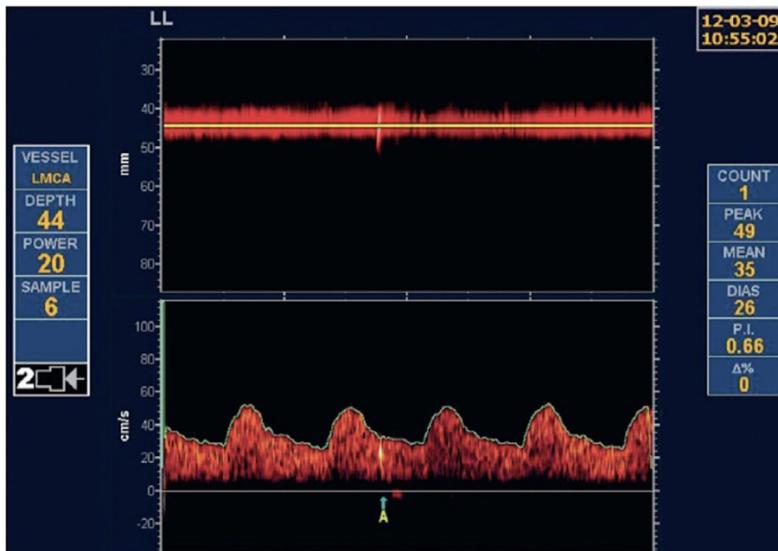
Microembolic signal on transcranial Doppler. Upper panel: M-mode recording; the arrow points to an image of a microembolus. Lower panel: the Doppler velocity envelope; the arrow (A) points to the high-intensity transit signal created by a microembolus. From Spence JD. Transcranial Doppler: uses in stroke prevention. *J Vasc Ultrasound* 2015;39:183–7 [21], reprinted with permission.
